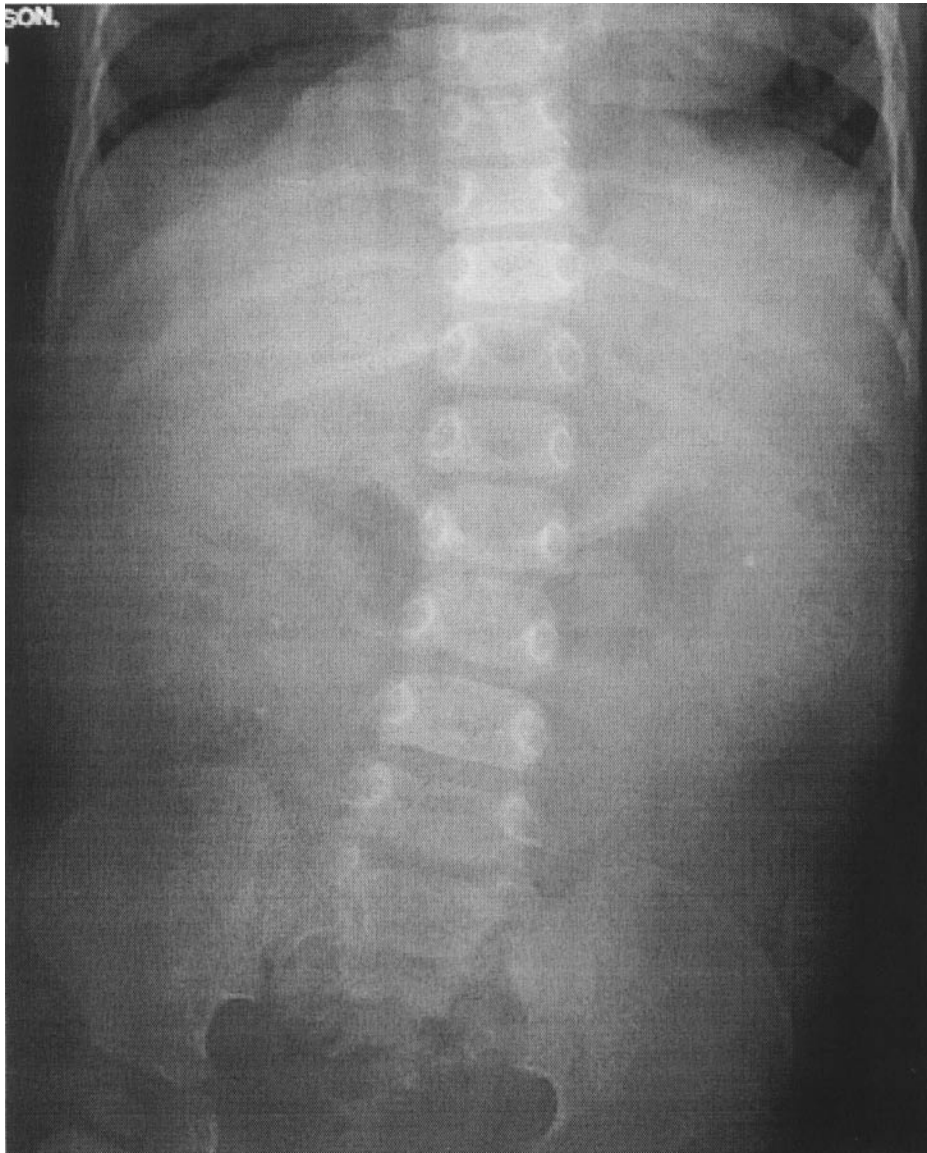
Abdominal radiograph demonstrating several radiopaque densities consistent with lead chips in patient 3.
